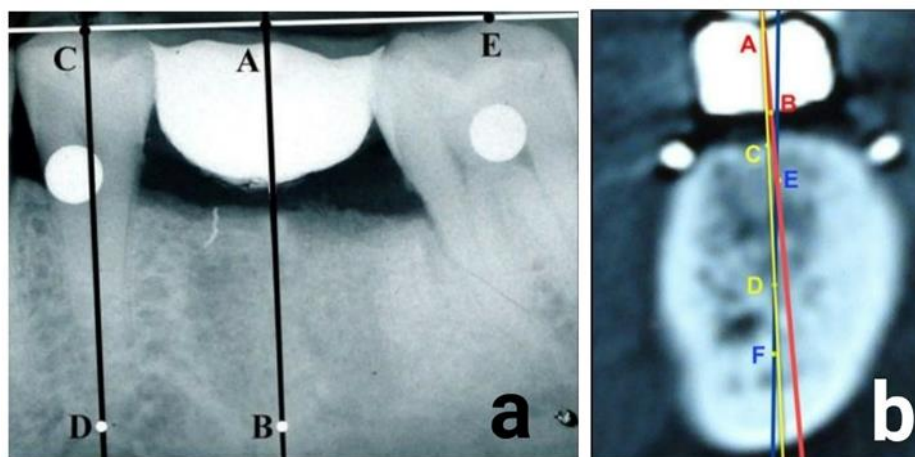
a: AB- Optimal mesiodistal angulation of the implant plotted on radiograph
